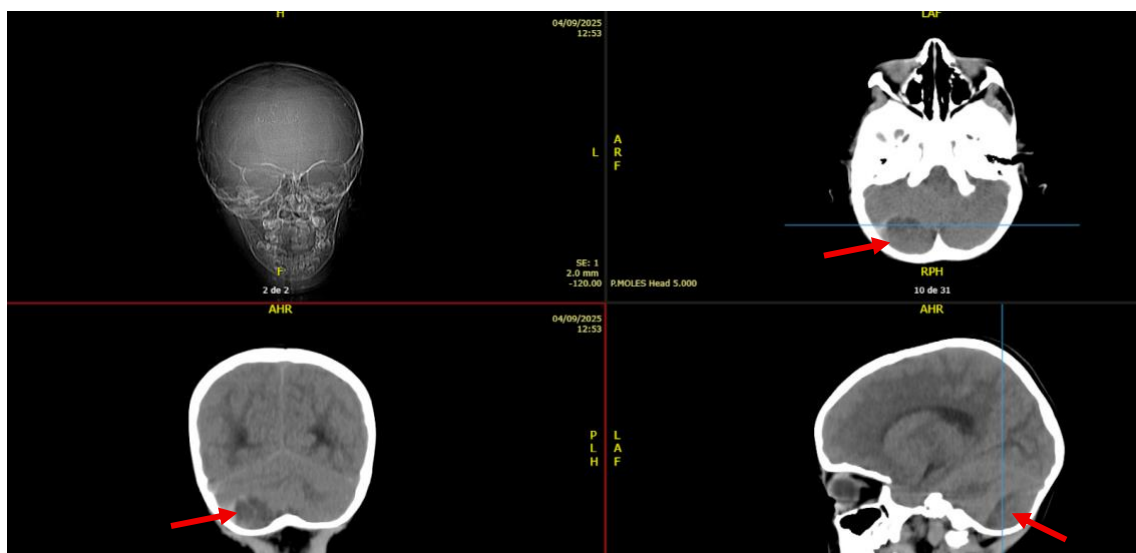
Computed tomography (CT) scan of the skull showing a right posterior fossa epidural hematoma (red arrows), without bone fracture.
